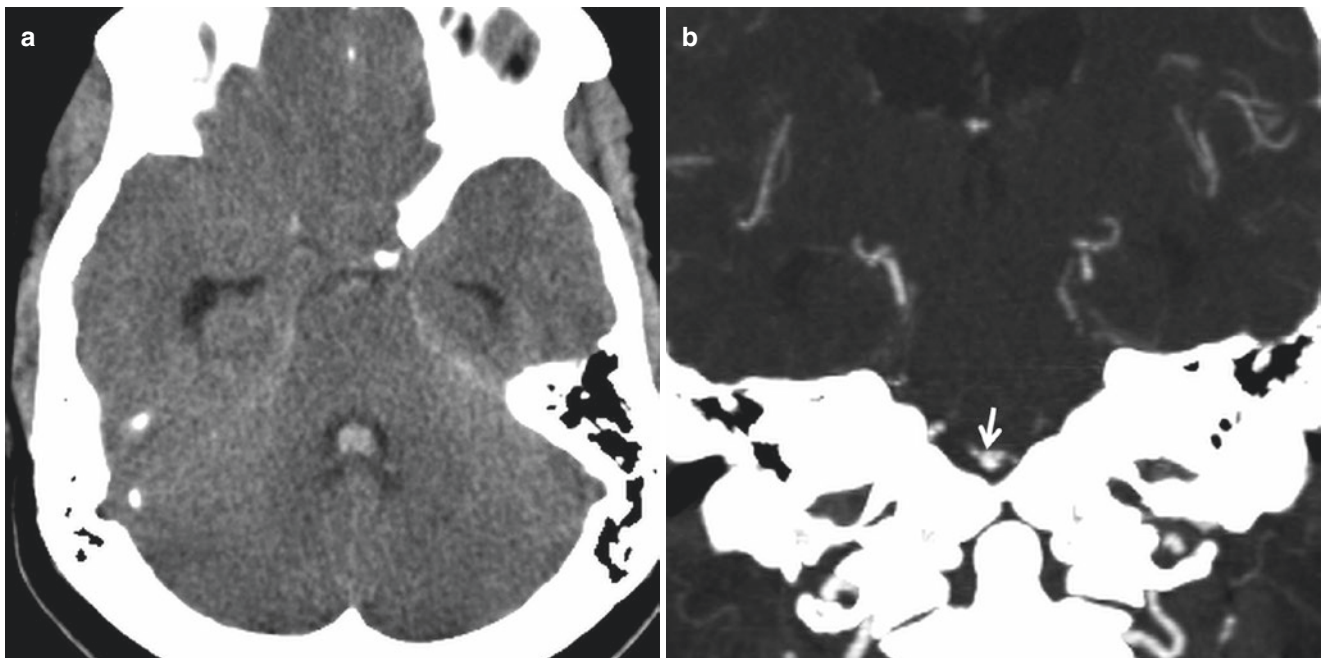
Dissecting vertebral artery aneurysm. Young patient with acute headache. (a) NCCT shows a small amount of fourth ventricular hemorrhage and hydrocephalus. (b) Coronal CTA demonstrates a small aneurysm originating from left vertebral V4 segment (arrow). (c) 3D volume-rendered CTA reformation shows a fusiform aneurysm of V4
